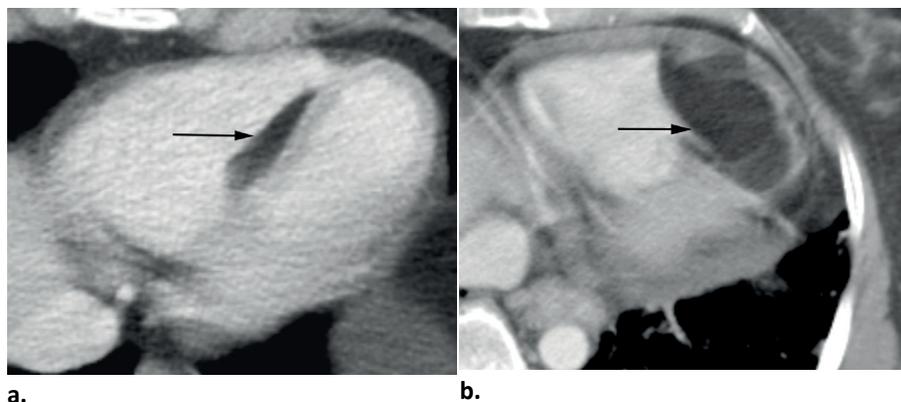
Nongated contrast-enhanced abdominal CT images in patients with TSC show fatty foci in the myocardium. (a) Image in 25-year-old man shows fatty focus in the interventricular septum (arrow). (b) Image in 45-year-old woman shows large fatty focus with mass effect in apex of the left and right ventricle (arrow).
